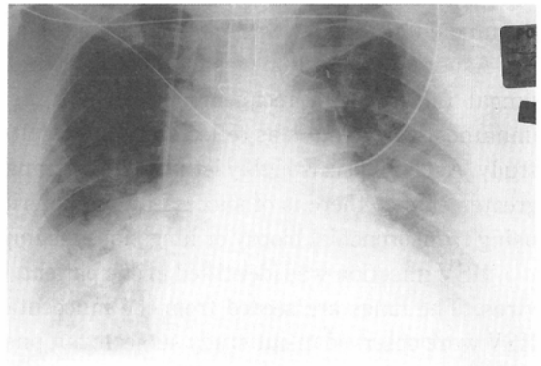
(Case 7) HSV infection. AP portable chest radiograph 0.5 months after cardiac transplantation shows diffuse patchy and confluent opacities.
